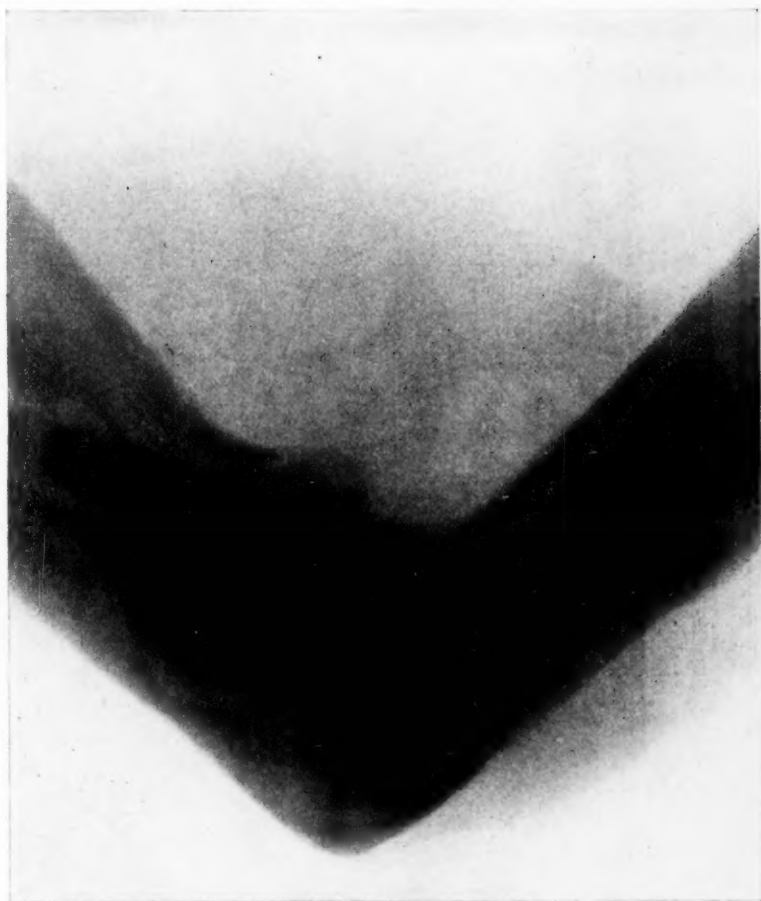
Radiograph showing contracture of right elbow joint. Sprain caused by "putting the shot."
